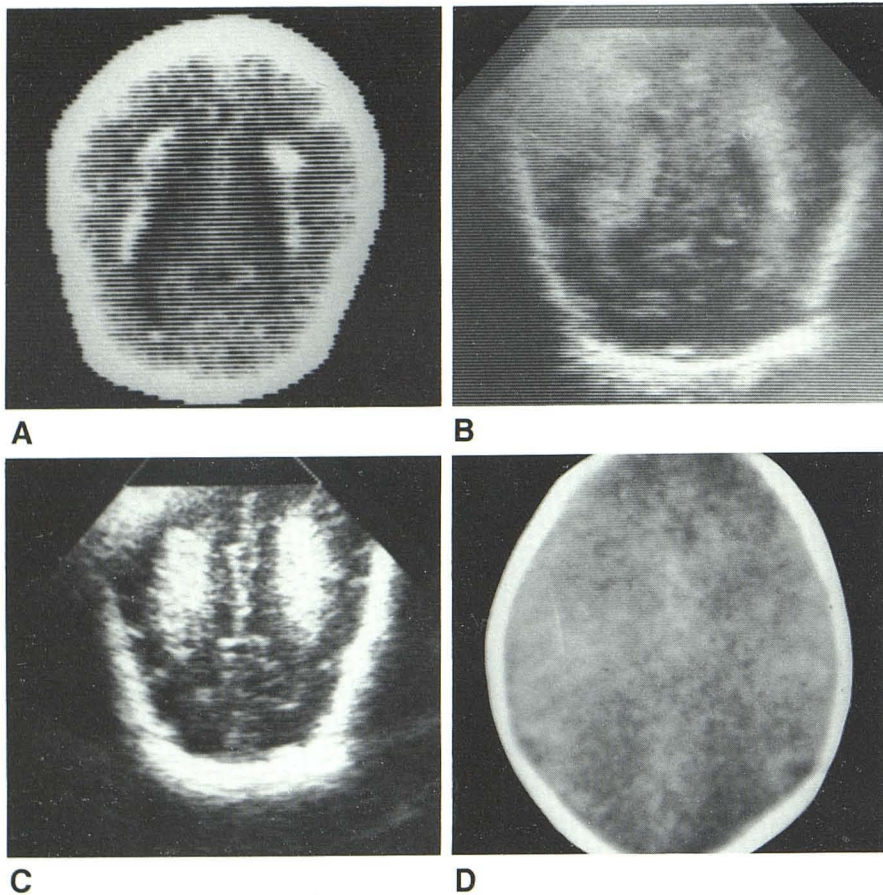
Hemorrhagic and nonhemorrhagic PVL. A and B, Hemorrhagic PVL with increased attenuation on CT and echogenic centrum semiovale on sonogram. C and D, Nonhemorrhagic PVL produces periventricular low density on CT and similar high-level echoes on sonogram.
